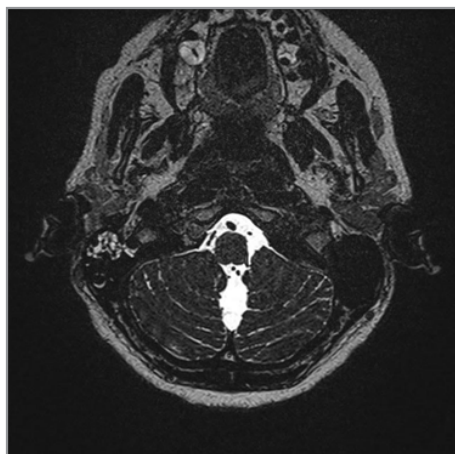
(MRI scan: liquid and viscous content in the remaining mastoid cells)
